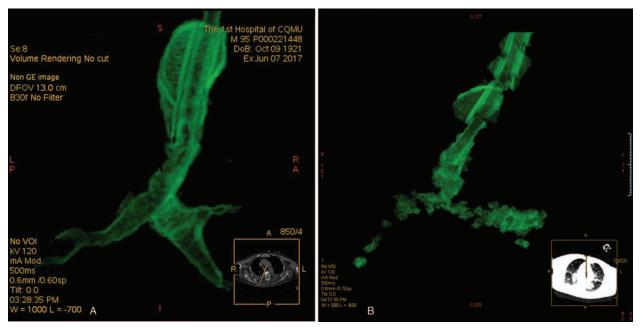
Three dimensional computed tomography reconstruction of the airway on day 240 (A) and day 329 (B) after ETI.
